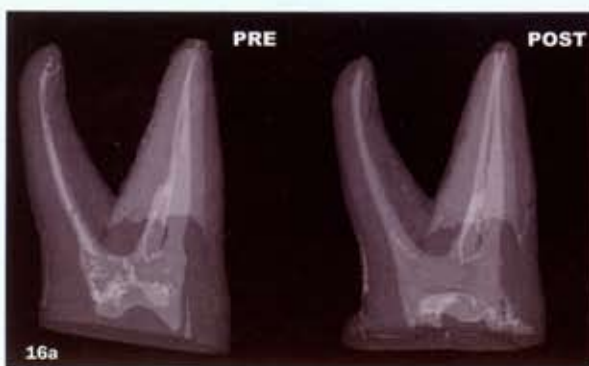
Pre-instrumentation (left) and post-instrumentation (right) root canal cross-section of a second upper premolar with oval anatomy obtained by means of  $\mu$ CT scanning and reconstruction (in collaboration with R Bedini and R Pecci – Italian National Institute of Health, Technology and Health Department, Rome, Italy)
